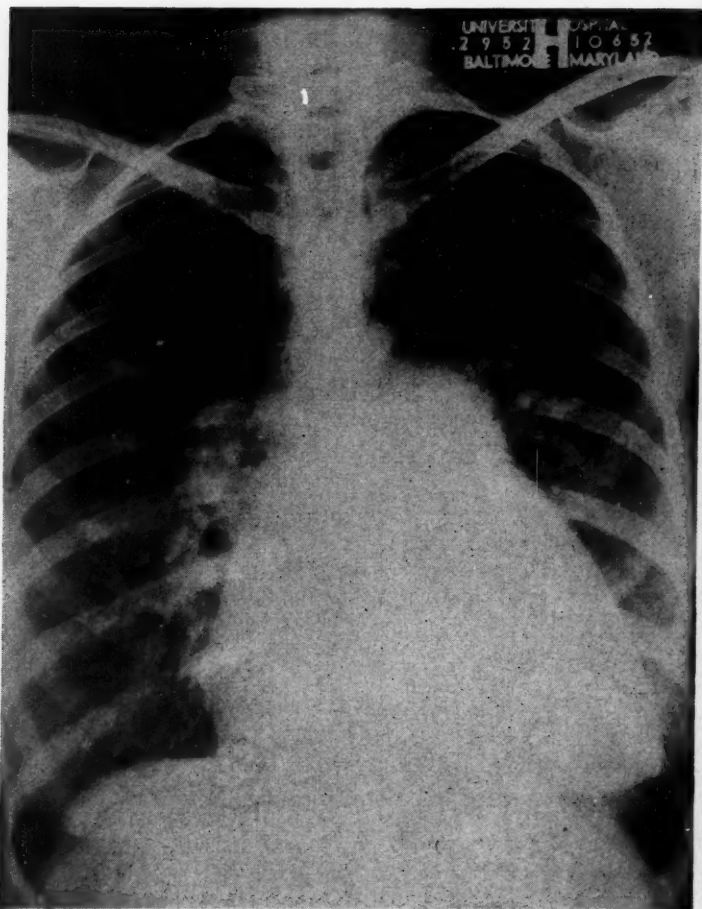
Roentgenogram. The heart is enlarged to the right and left. The pulmonary artery segment is extremely prominent.
